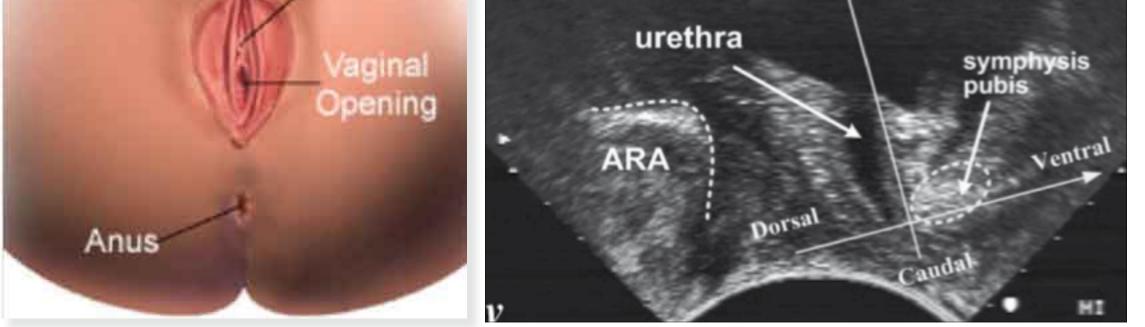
(a) Mid sagittal position of transducer during transperineal (TP) imaging; (b) Typical transperineal view on an ultrasound scan with co-ordinate system placed on symphysis pubis, parallel and vertical to the urethra. P = posterior edge of the urethra; A = anterior edge of urethra. Reproduced with kind permission [2]
